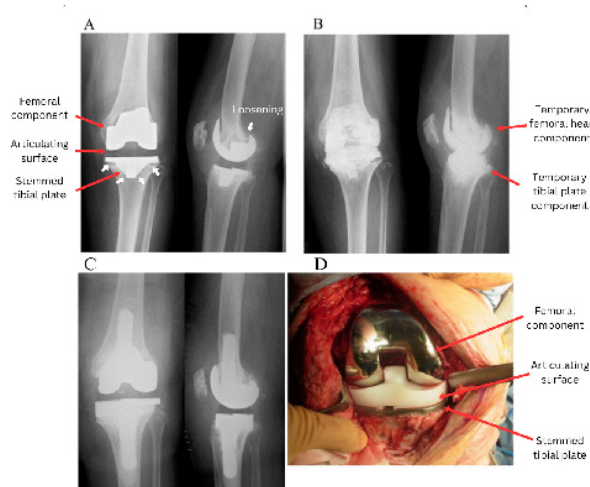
Two-stage revision total knee arthroplasty (rTKA) for the treatment of periprosthetic joint infection. (A) Pre-operative radiograph as evident implant loosening was found, (B) pre-operative radiograph before to the second surgical procedure shown that implantation of articulating cement spacers containing antibiotics was performed, (C) The radiograph at the final follow-up showed that the rTKA was completed without implant loosening, and (D) The macroscopic image depicts the TKA prosthesis (23).
